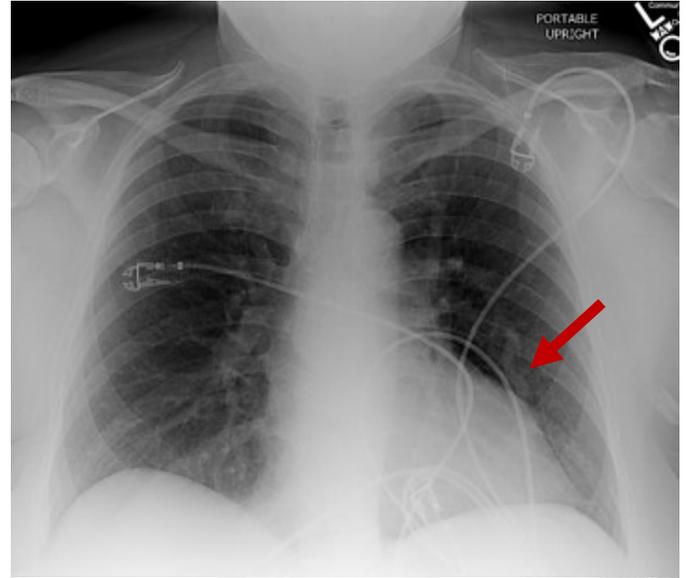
Chest x-ray with visible AVM pre- AJ4794 and post-coiling.
